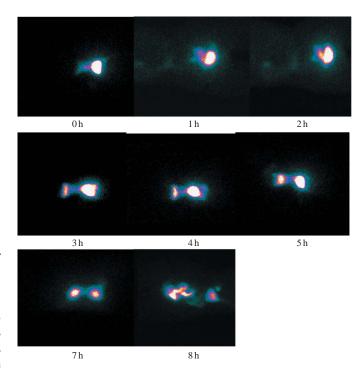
Gamma scintigraphic images of ion-exchange fiber in fasted volunteers.
